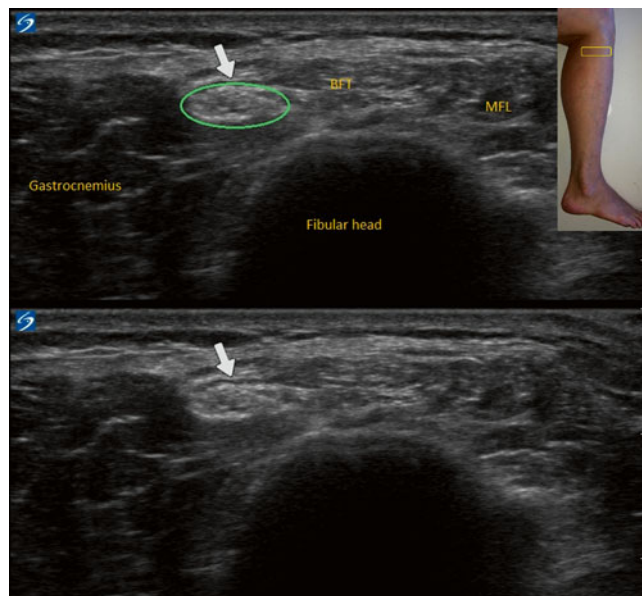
Ultrasound image of the common peroneal nerve (arrow) at the fibular head before the split into the deep and superficial peroneal nerves. MFL fibularis longus muscle, BFT biceps femoris tendon (image courtesy of Agnes Stogicza, MD)
